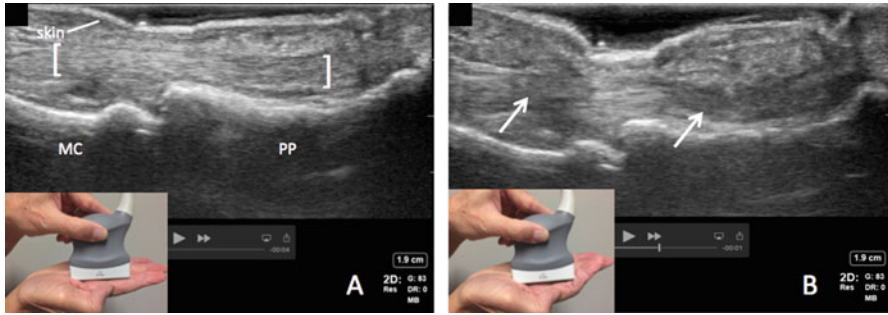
Demonstration of anisotropy in the long flexor tendons of a digit of the hand. In the fully extended digit (a), maximal reflection of the flexor tendon is seen because the ultrasound beam strikes the tendon at near 90 degrees. In a slightly flexed digit (b), the beam strikes parts of the tendon at less than 90 degrees, producing areas of anisotropy (arrows). The skin is in the near field. The tendon is shown between the brackets in (a). MC, metacarpal bone; PP, proximal phalanx. Note the shadows in the far field due to the bones. The insets show the transducer positioned over the metacarpophalangeal joint
